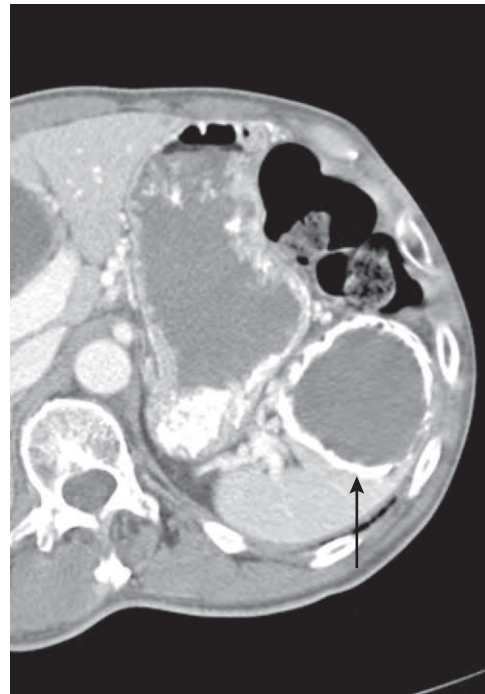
Axial contrast-enhanced computed tomography scan demonstrating a calcified splenic hematoma (*arrow*).
